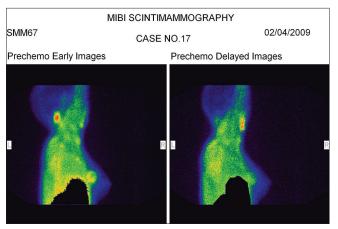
Patient no. 17 (responder case) - shows early and delayed images of scintigraphy studies of breast, who showed good response to chemotherapy on pathological examination. It evidenced intense tracer uptake in tumor in early image and low wash out rate in delayed image predicting good response to chemotherapy
